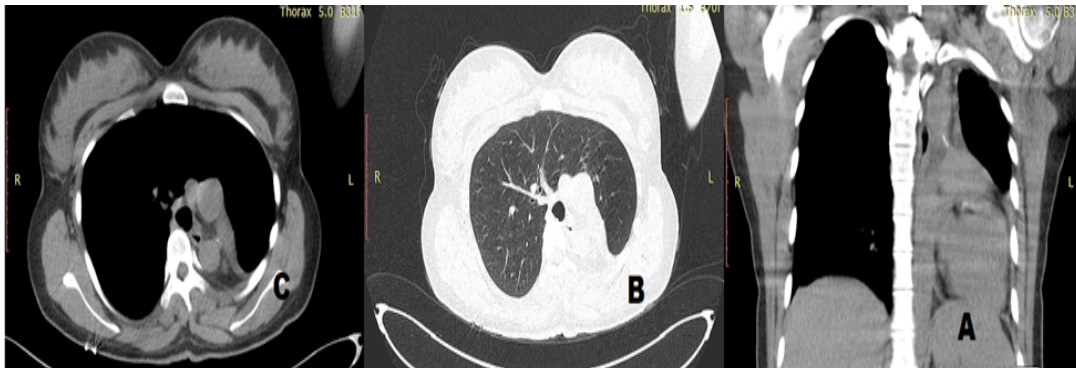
CT scan showing complete atelectasis of the left lung with short-blind left main bronchus and compensatory hyperinflation of the right lung.
